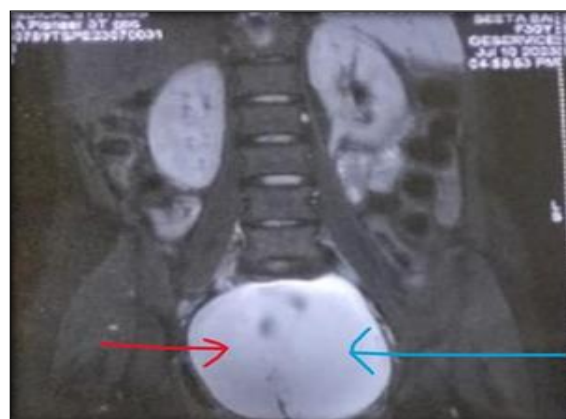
MRI shows a Case of Anterior pre-sacral epidermoid tumor in 30 years old female operated by posterior approach (Red arrow shows bladder and blue arrow shows tumor)
